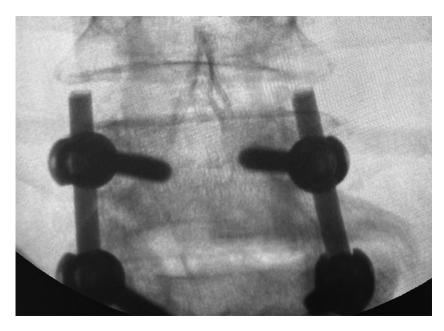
Intraoperative radiographic control image of the lumbar spine in the anteroposterior view. The transpedicular fixation system is installed at the L4/L5 level
